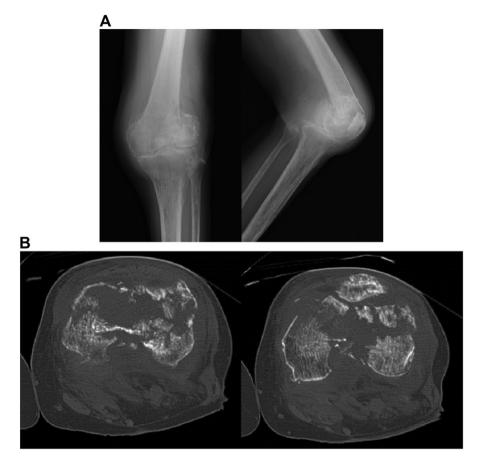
(A) Anteroposterior and lateral radiographs showing a displaced comminuted supracondylar and intercondylar fracture; (B) coronal computed tomography scan images revealing extensive comminution of the bilateral condyle and avulsed fragments of the collateral and cruciate ligaments.
